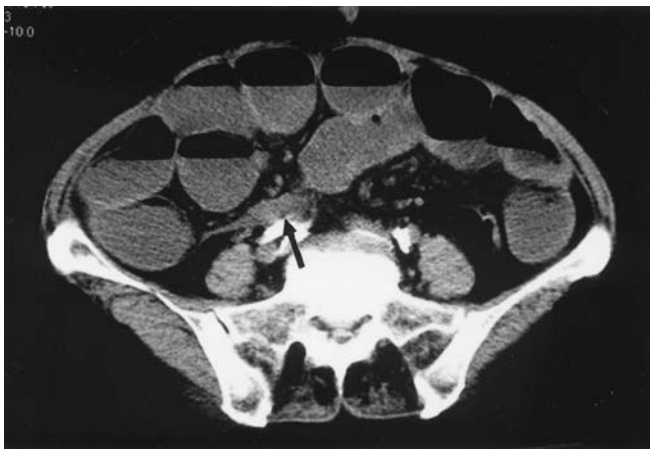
CT scan (first medical examination) of the stenosis of the terminal ileum (*arrow*)
